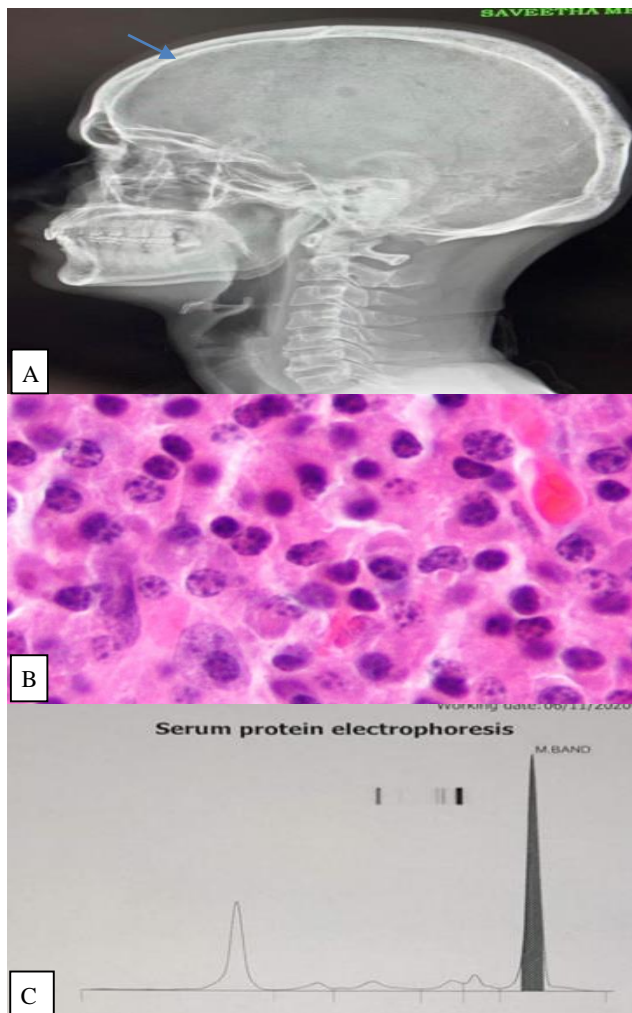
(A-C): X-ray skull showing multiple punched-out lesions representing osteolytic activity. Image 2-characteristic plasma cell (round or oval cells with an eccentric nucleus composed of coarsely clumped chromatin, dense basophilic cytoplasm). Serum electrophoresis shows M-band highly suggestive of multiple myeloma.
